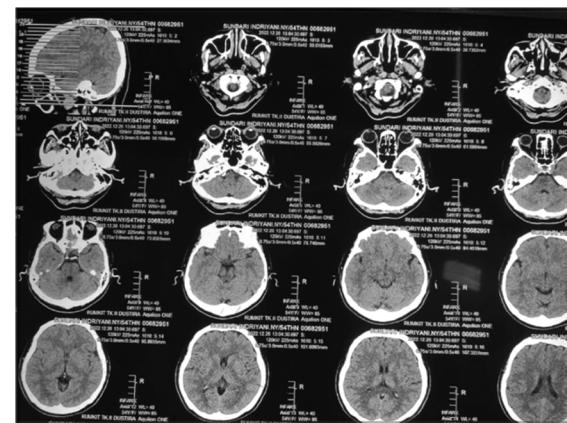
CT head demonstrating chronic lacunar infarcts in the basal ganglia region
